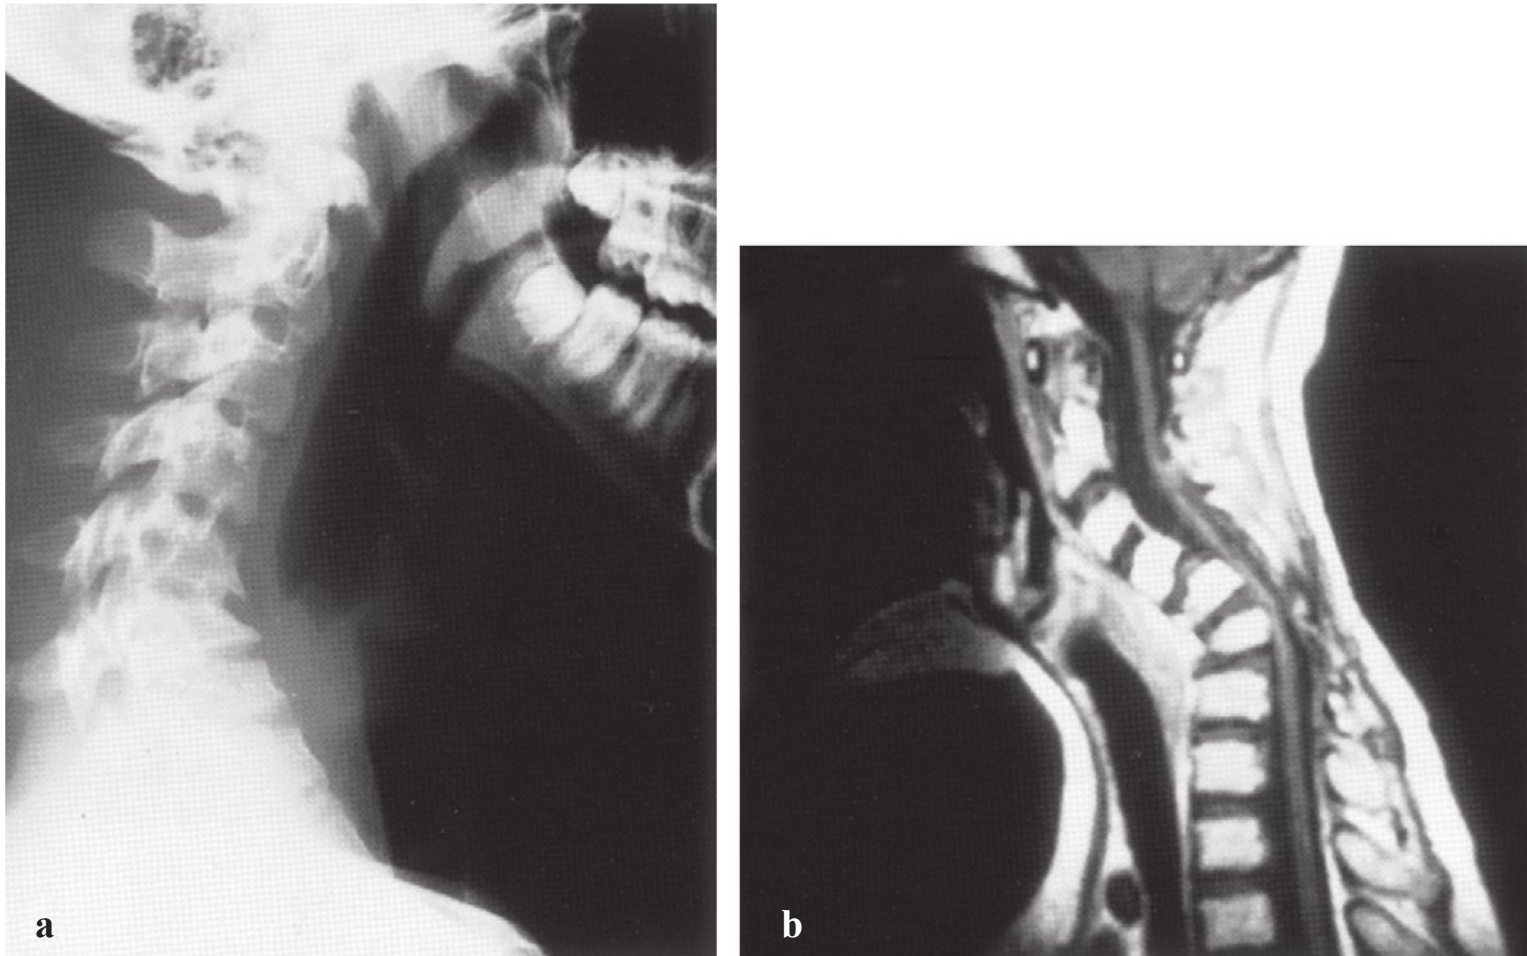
Cervical kyphosis. (a) Lateral radiograph of a 17-year-old patient with cerebral palsy who presented with severe thoracic lordosis and cervical kyphosis with progressive myelopathy. This patient underwent anterior vertebrectomy and fusion and subsequent surgical procedures for correction of his thoracic lordosis. (b) Magnetic resonance imaging of a 14-year-old boy with postlaminectomy kyphosis and myelopathy. Anterior corpectomy and fusion were required for correction.
